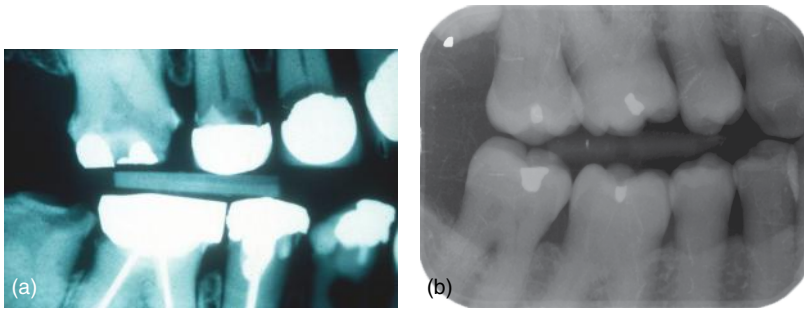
(a) Bitewing radiograph of a 50-year-old woman (a dentist's daughter) born in 1944. A very heavily restored dentition is obvious with many new caries lesions around the restorations. Many of these teeth are now unrestorable. (b) Bitewing radiograph of a 70-year-old woman (a hygienist's daughter) also born in 1944. There are very few restorations.
